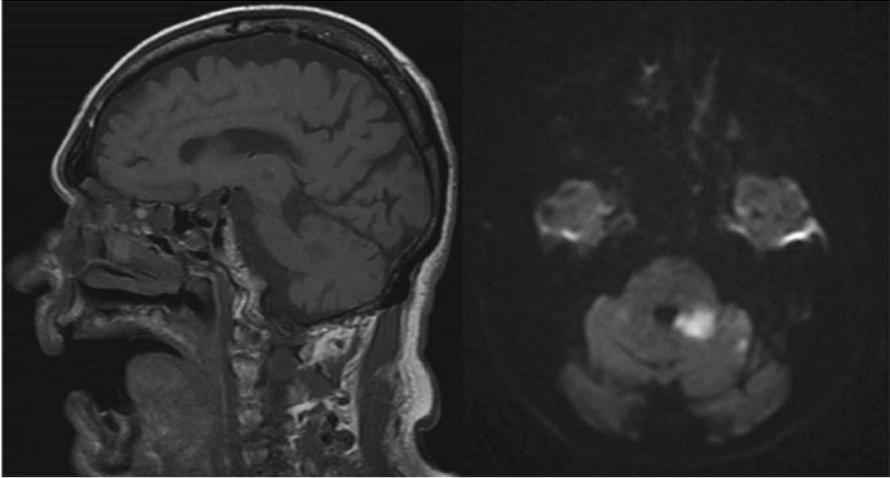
MRI sagittal T1 (*left*) and axial diffusion-weighted scan showing an AICA territory infarct
